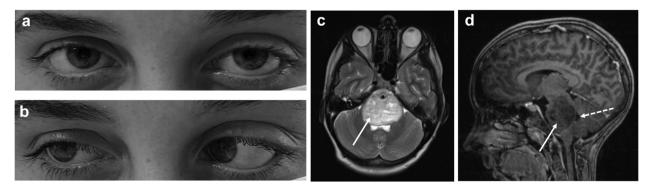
Eye photography (a, b) and magnetic resonance imaging (MRI, c and d) of patient (a) Photography of the eyes in primary position, showing right esotropia. (b) – photograph, showing limited abduction in the right eye. (c) – Axial T2WI of the brain showing hyperintense pontine lesion (solid arrow). (d) - Sagittal post-contrast T1WI of the brain showing the lesion extending into the inferior medulla (solid arrow), and compression of the fourth ventricle (dotted arrow).
